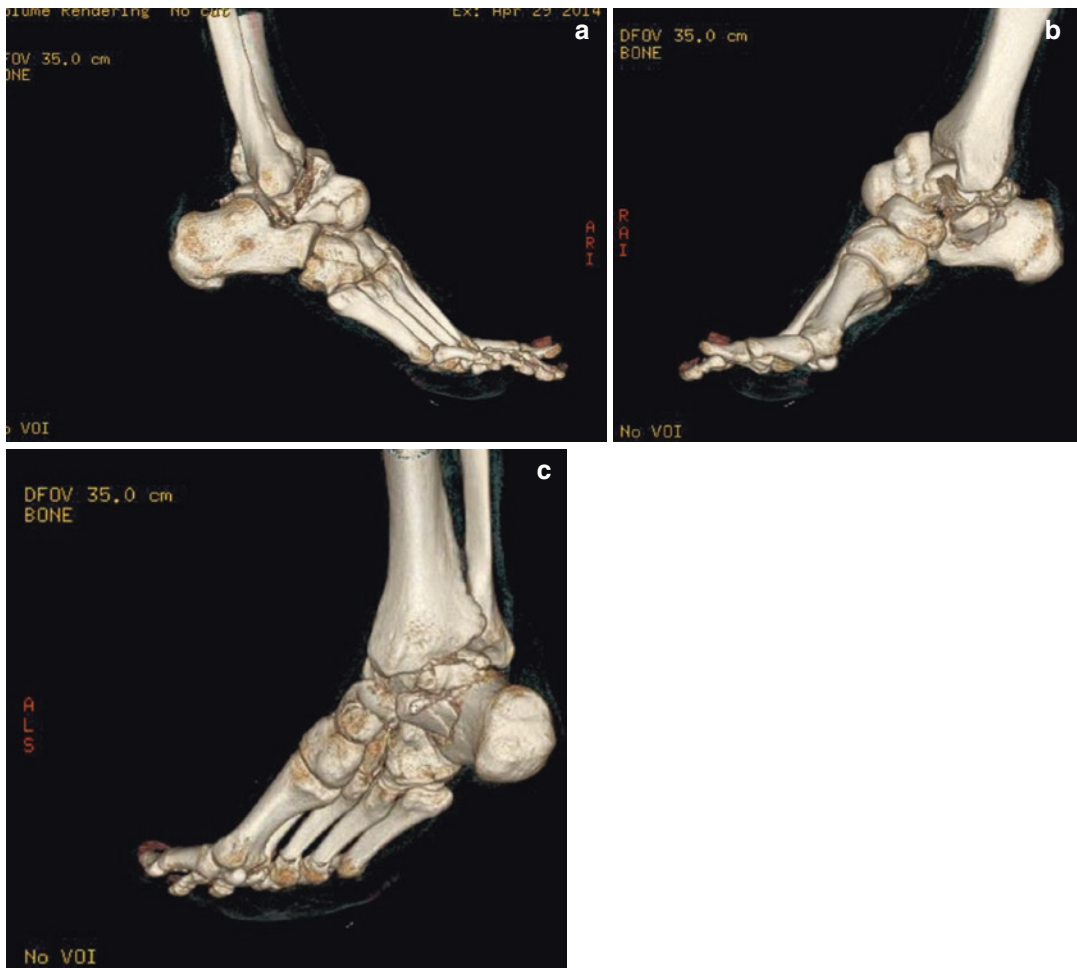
(a–c) A 3D CT reconstruction demonstrating a talar body and neck fracture with talar dislocation and sustentaculum fracture
